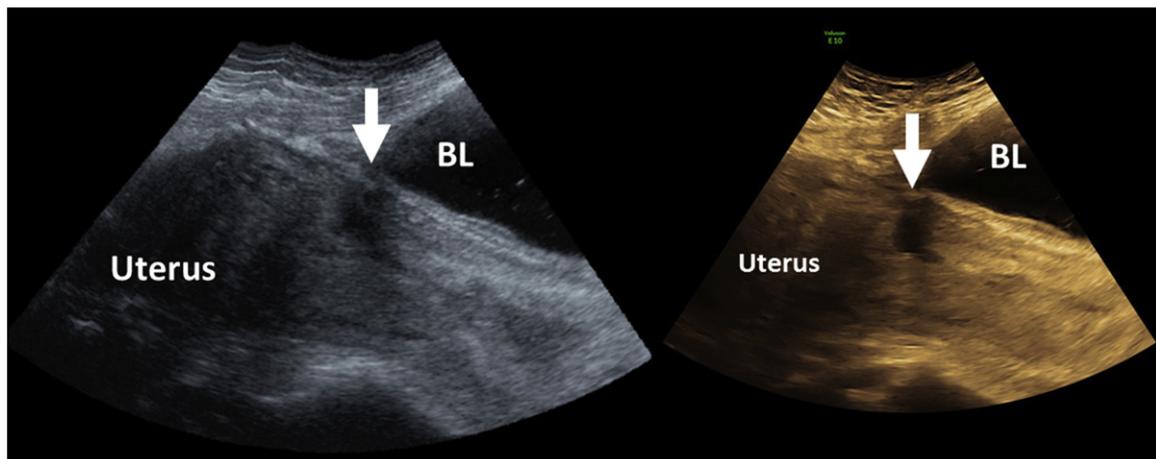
Transabdominal ultrasound images showing uterine wall defect (arrow) in the anterior aspect. BL-Bladder.
